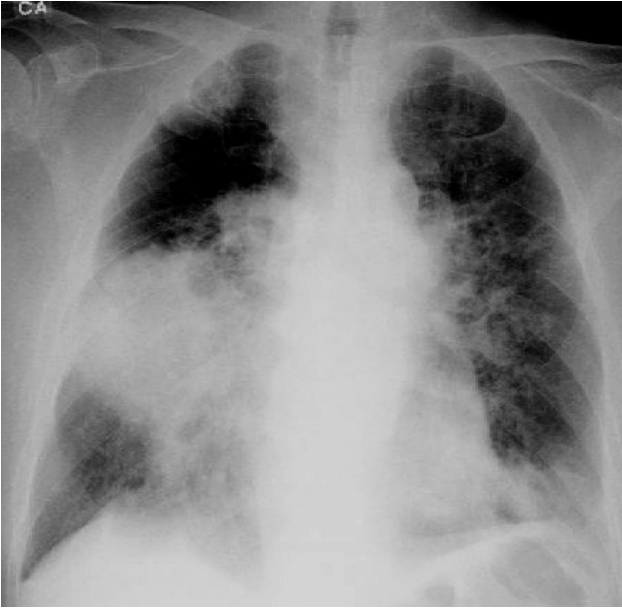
Chest radiograph shows diffuse fibrotic changes in the left lung and a mass-like infiltrate extending from the right hilus to the lateral chest wall.
